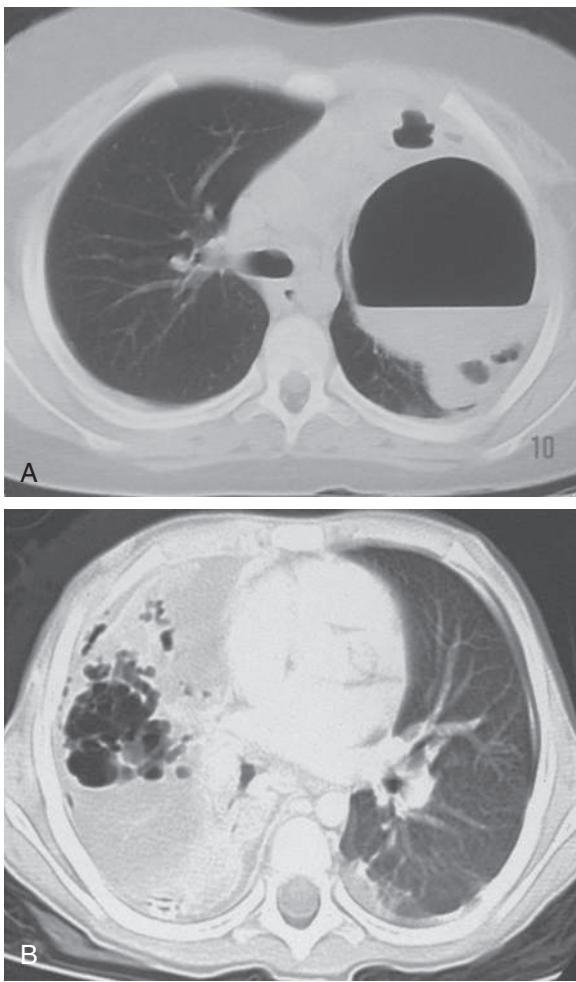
Chest CT in complicated community-acquired pneumonia. A, Lung abscess. A large cavity containing an air-fluid level can be seen. B, Necrotizing pneumonia with cavitation. (From de Benedictis FM, Kerem E, Chang AB, et al. Complicated pneumonia in children. Lancet. 2010;396:786–798, Fig. 4, p. 790.)
